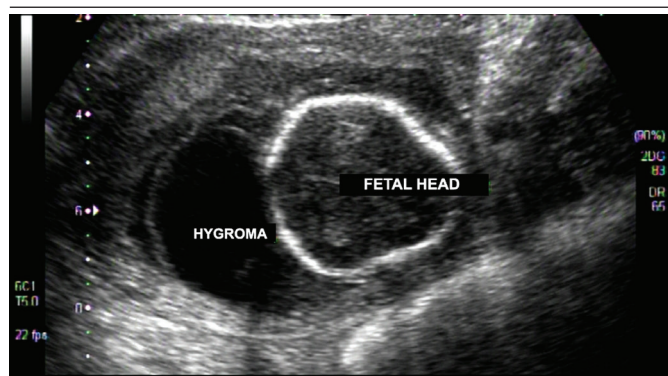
Fetal ultrasound performed at 16 weeks of gestation showing the cystic hygroma
